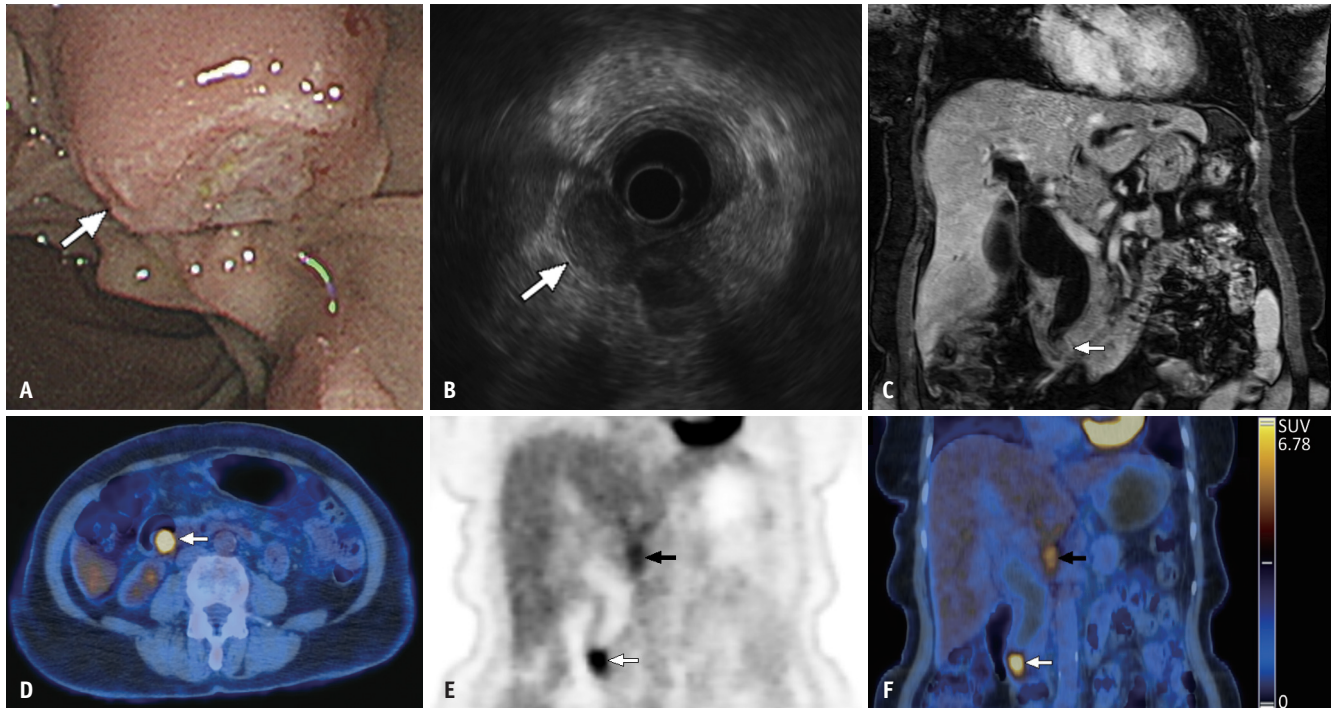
A 70-year-old female with a painful biliary obstruction was found to have an elevated CA19-9 level (51.6 U/mL). A-F: Endoscopy identified villous mucosal change of the ampulla without ulceration, bleeding, or friability (arrow, A). Endoscopic ultrasonography revealed a 16.6 mm hypoechoic tumor limited to the ampulla (arrow, B). There was no submucosal invasion or intraductal growth. The biopsy revealed a high-grade dysplastic neoplasm. Magnetic resonance imaging showed insignificant change of the ampulla (arrow, C) despite a marked dilated bile duct. 2-^[18F]FDG PET/CT revealed a hypermetabolic ampulla with an SUVe of 3.2, retention index of 34%, and total lesion glycolysis of 23.5 (white arrows, D, E, F). The ampulla of Vater was clearly delineated using oral contrast (arrow, D). A few positive nodes near the hepatic artery were also visualized (black arrows, E, F). The patient was considered to have a low risk of cancer according to endoscopy and clinical presentation and was considered to be eligible for endoscopic papillectomy. However, a multimodal risk score of 4.9 was obtained after combining 2-^[18F]FDG PET/CT information, indicating a high risk of occult malignancy. She received pancreaticoduodenectomy, and the final diagnosis showed adenocarcinoma of intestinal type. CA19-9 = carbohydrate antigen 19-9, 2-^[18F]FDG PET/CT = 2-^[18F]fluoro-2-deoxy-D-glucose positron emission tomography/computed tomography, SUVe = blood-pool corrected peak standardized uptake value in early-phase scan
